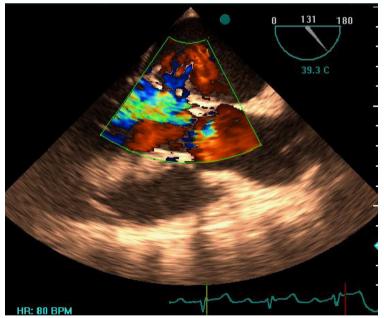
The color Doppler flow showed that the aneurysm was filled with flow during systole without any communication with left atrium
